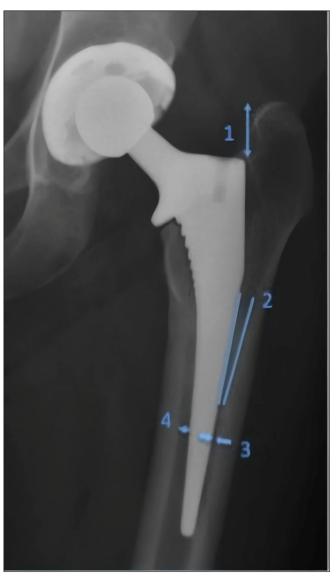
Radiographic analysis parameters. 1: distance from tip of greater trochanter to implant shoulder; 2: angle portended between lateral cortex and lateral implant surface; 3: distance between lateral cortex and lateral implant surface; 4: distance between medial cortex and medial implant surface.
